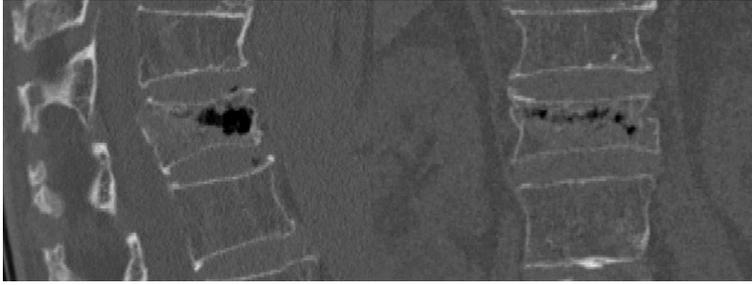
CT imaging of KD patient (Left: sagittal position; Right: coronal position).
